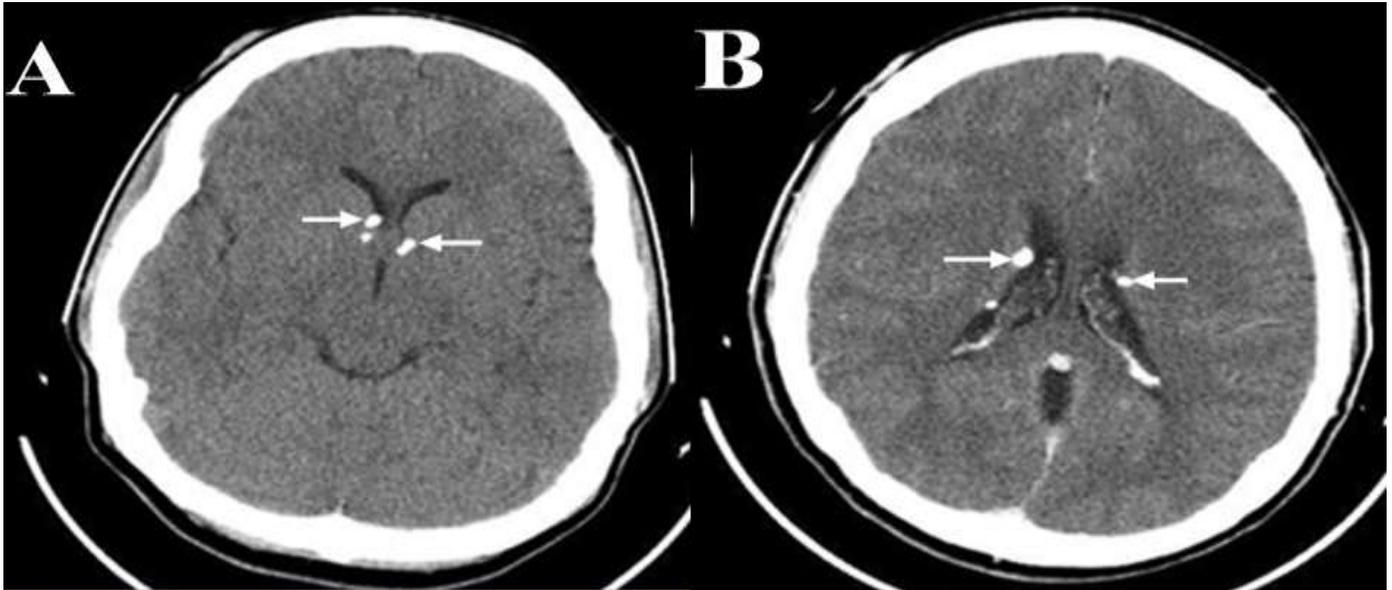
Axial CT at the level of the frontal horns (A) and bodies of the lateral ventricles (B) showing multiple calcified subependymal tubers (arrows).
